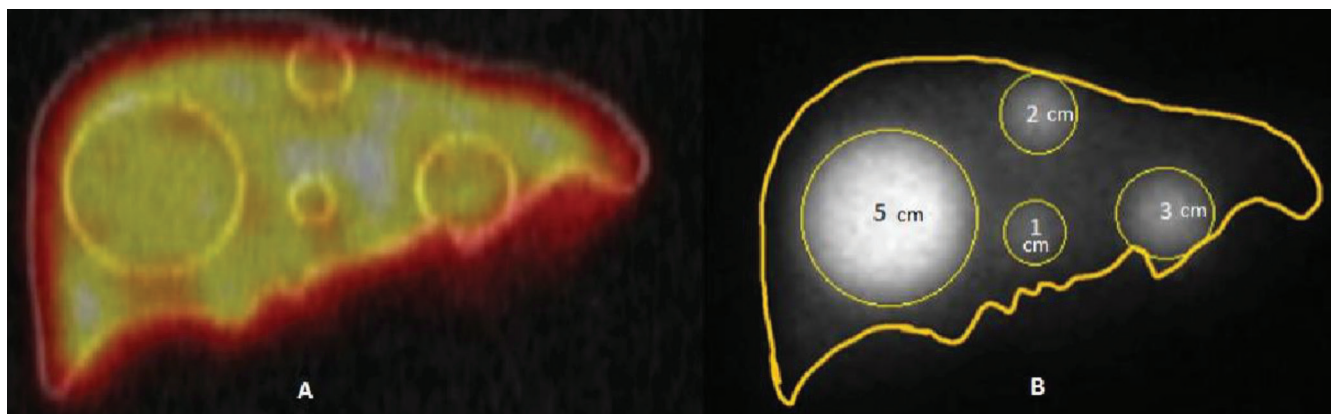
SPECT/CT fusion VOI images showing the CT image of the lesions (A). In the planar image, the numbers inside the ROIs represent the lesion diameters (B)
